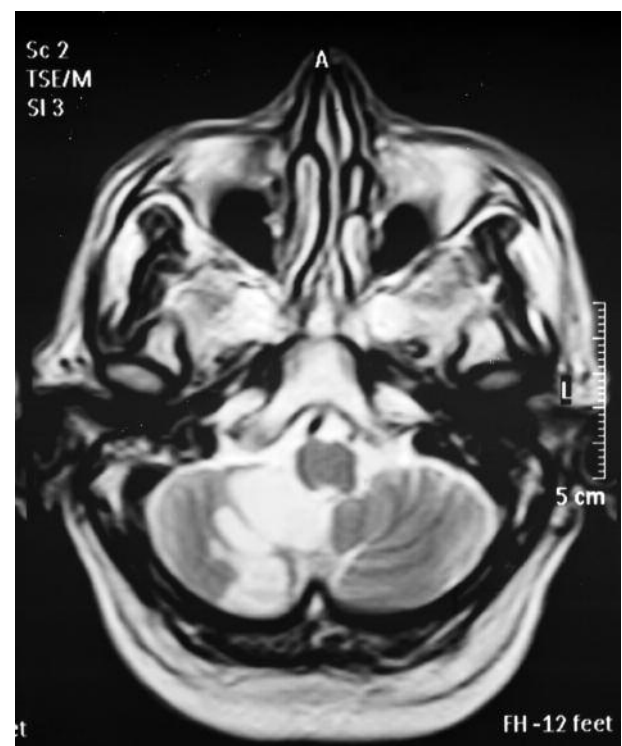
Axial T2-weighted brain magnetic resonance imaging scan shows hemorrhagic infarct in the right cerebellum.
